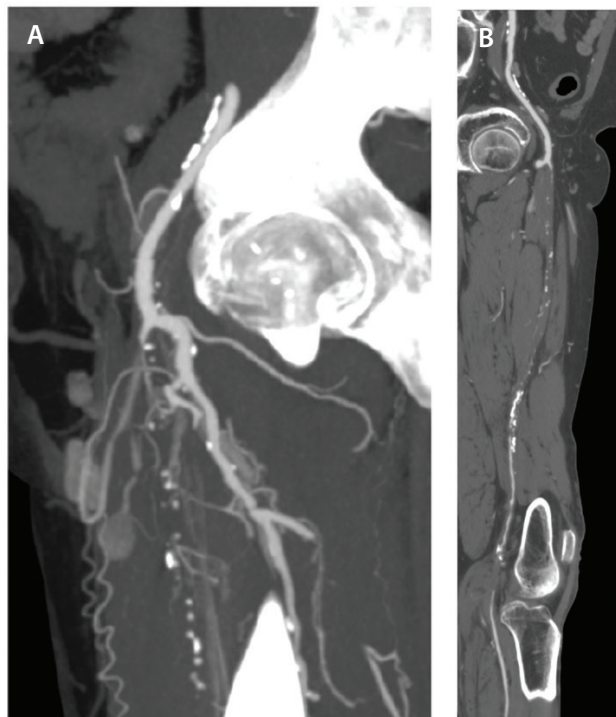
Preoperative CTA of the femoral artery showing the left CFA was free of disease, an occlusion of the SFA with a short stump, and focal significant stenosis of the distal popliteal artery (A). Preoperative CTA of the femoropopliteal artery showing CTO of the SFA and disease of the proximal popliteal artery with segmental occlusion (B).
